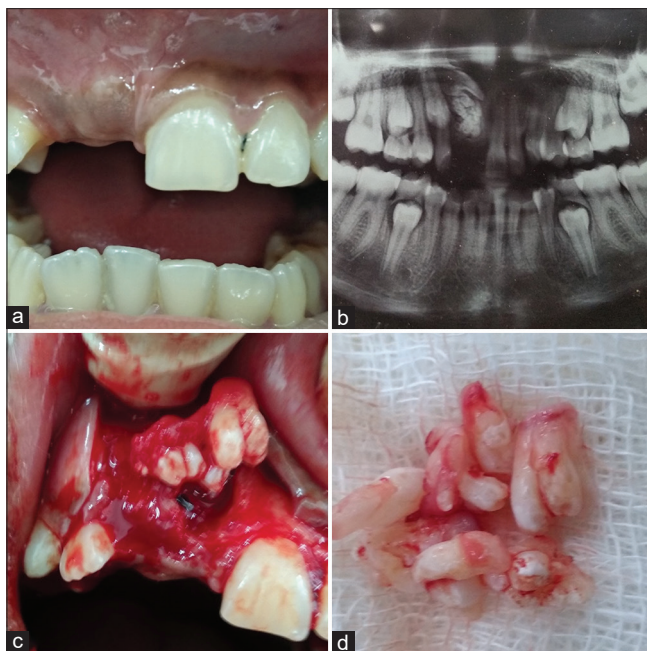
(a) Clinical photograph showing non-erupted right maxillary central incisor at the age of 11, (b) orthopantomograph showing the existence of overlapping radiopaque structures, indicative of a compound odontome adjacent to the horizontally impacted incisor, (c) full thickness mucoperiosteal flap was raised to expose the supernumerary tooth and odontome, and (d) extracted compound odontome
